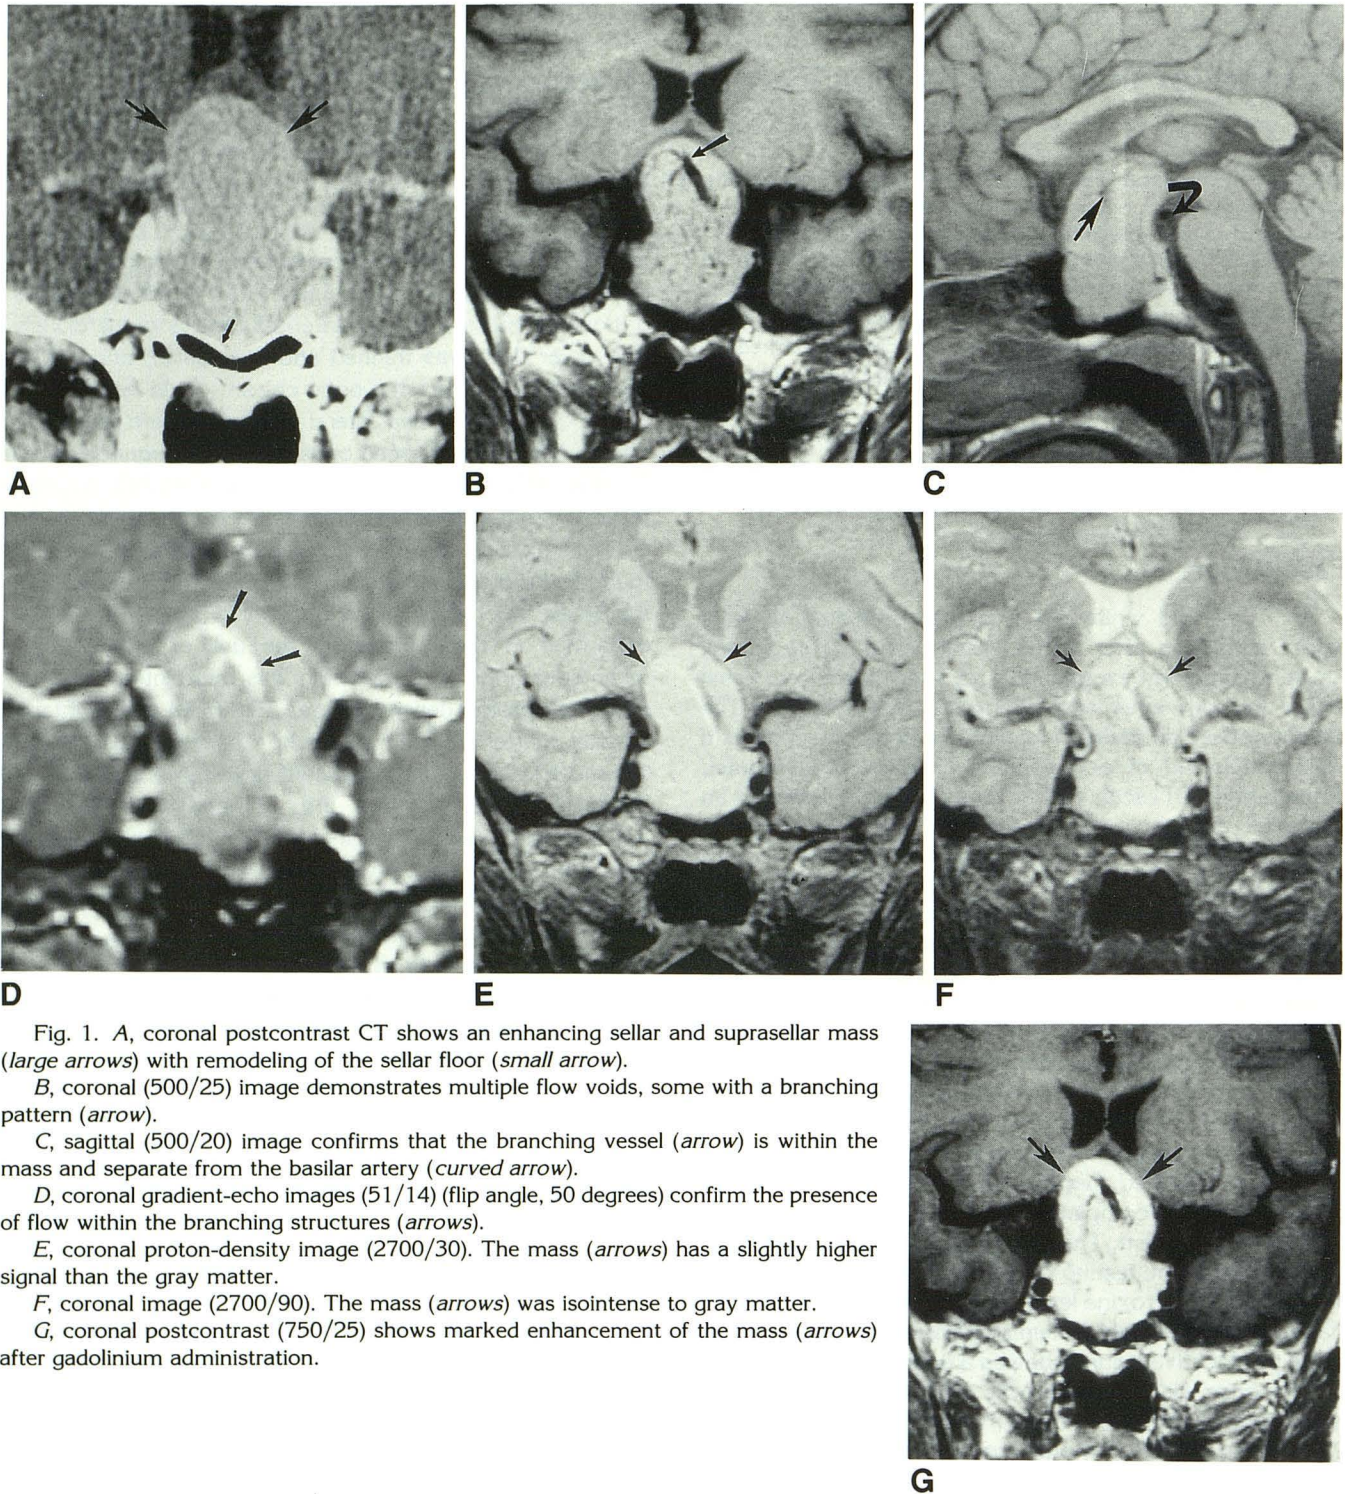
A, coronal postcontrast CT shows an enhancing sellar and suprasellar mass (large arrows) with remodeling of the sellar floor (small arrow).
